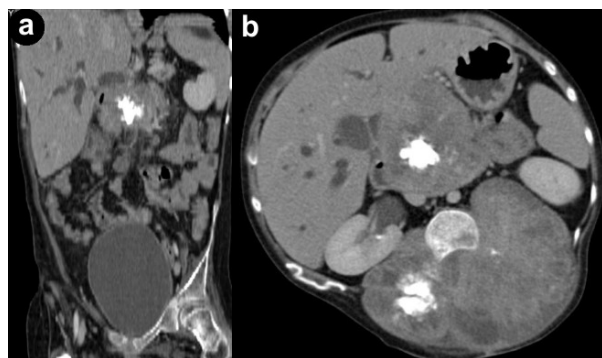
On abdominal CT a large metastatic mass with irregular contour was also visualized on pancreatic head and peripancreatic region having tomographic findings similar to the vertebral mass.
